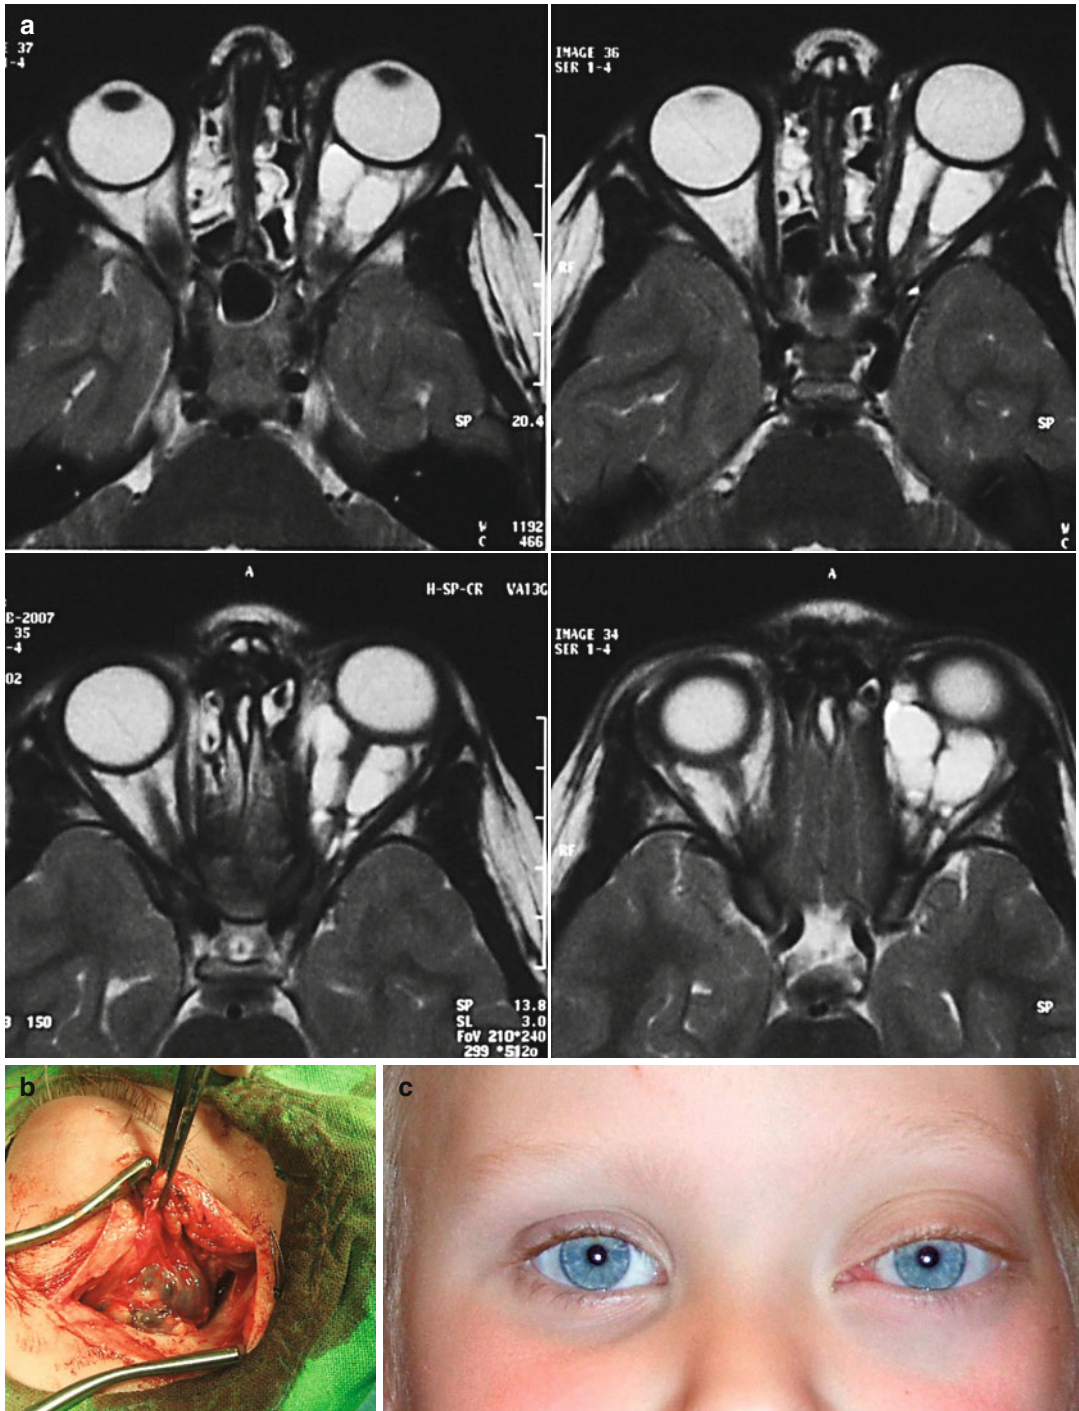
Hemorrhagic lymphangioma in the left orbit. (a) MR images. (b) Intraoperative photography. (c) Facial photography
